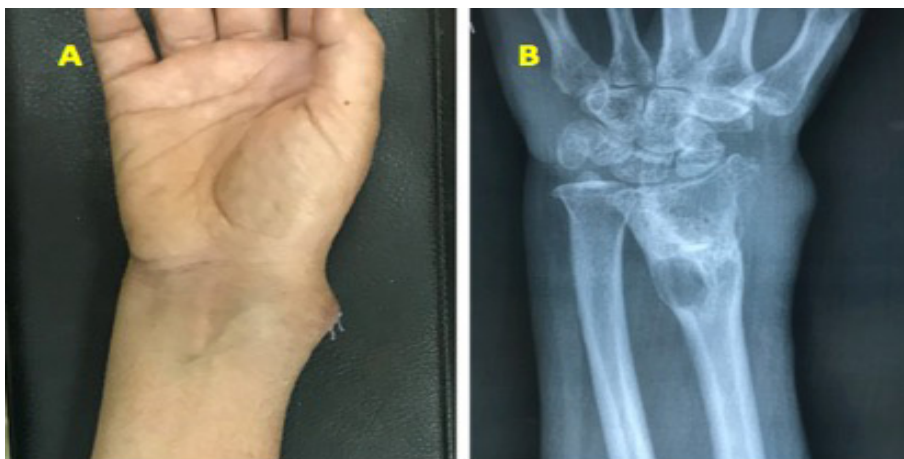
Pre-operation: (A) the right wrist is swollen and red on the radial side. (B) X-ray film: The right wrist demonstrating the osteolytic lesions of the distal radius
